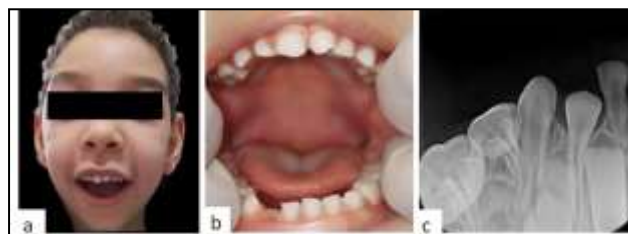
(a) Extra-oral Image; (b) Clinical absence of the unit 82; (c) Periapical radiography evincing unit 82.
